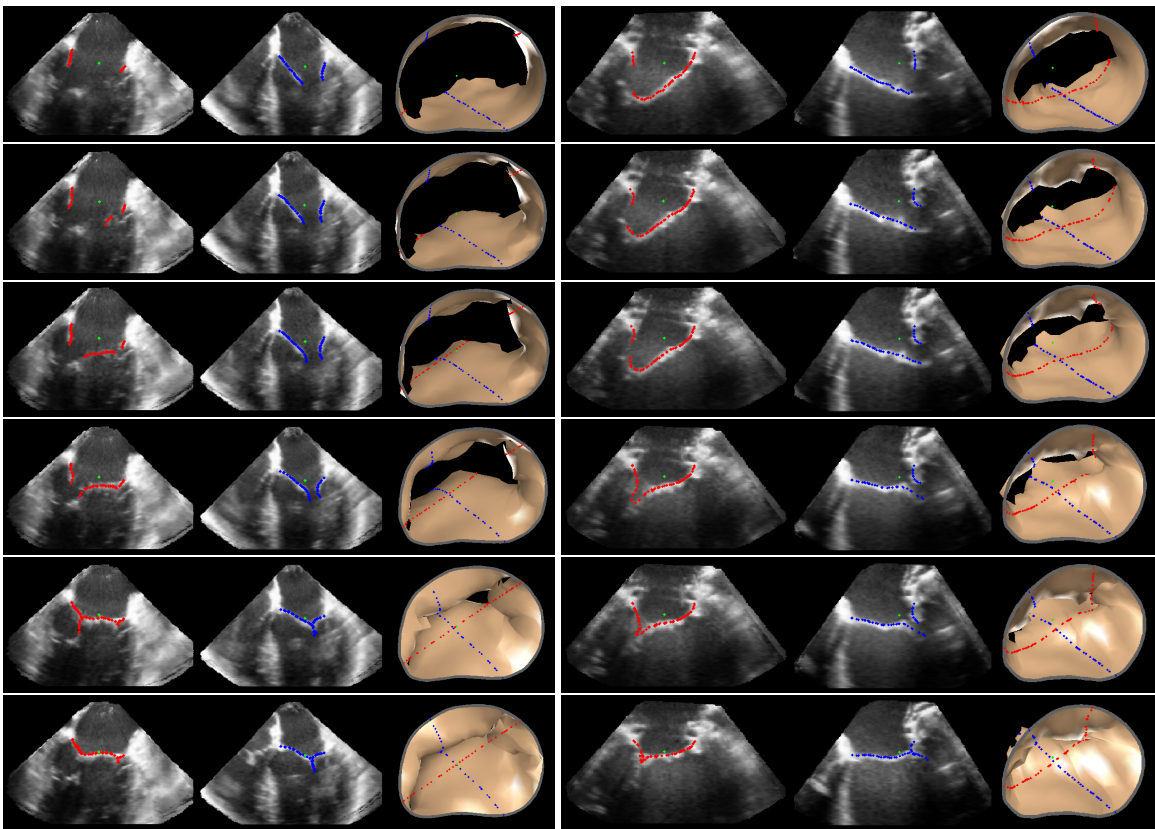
Results of the mitral valve segmentation method during valve closure for ( $1^{st}$  Column) a normal mitral valve and ( $2^{nd}$  Column) a stenotic mitral valve. The comparison of the mesh location in the image planes (red and blue points) relative to the leaflets as seen in the images show the effectiveness of the 4D mitral valve segmentation method for ultrasound.
